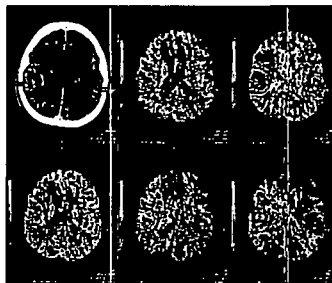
CT perfusion maps reveal a focal area of increased MTT in the right periorbital lobe. An ROI was drawn over this affected area as well as the contralateral hemisphere using an "auto mirror function". Note the increased CBF, increased CBF, elevated TTP and increased "Delay" in the affected area.
